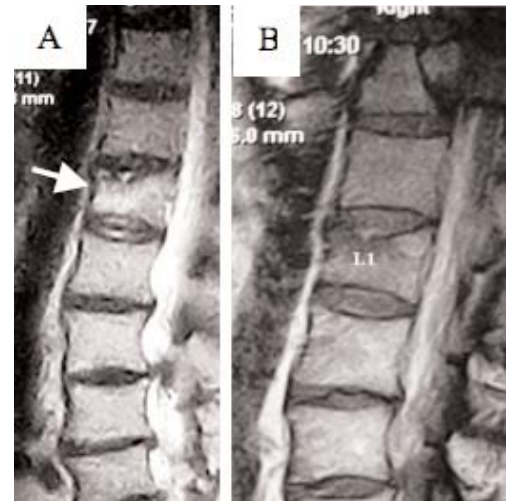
T-2 (A) and T-1 (B) weighted MRI, confirming a fracture with edema at the L1 level (arrow).
